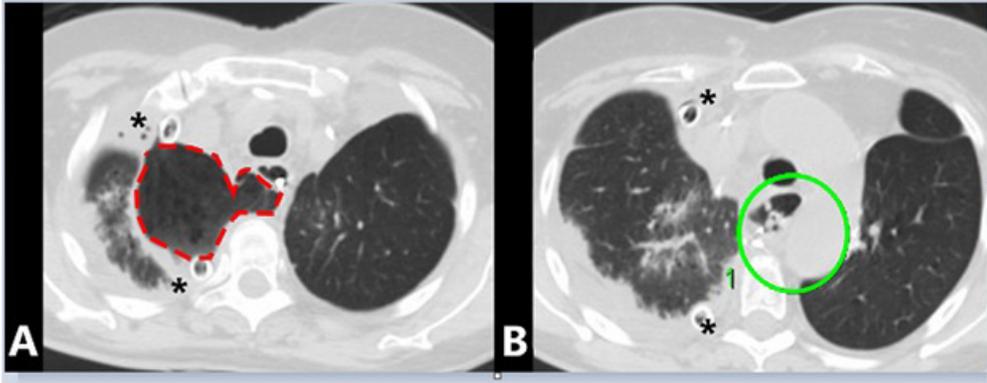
Thoracic CT scan showed a large upper mediastinal collection (67x74 mm in diameter – red dashed line) (A) secondary to an iatrogenic tear (green circle line) of the esophageal wall (B). The asterisk points at two chest tubes in place.
